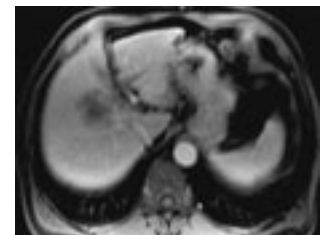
Contrast enhanced MRI at 6 months follow-up after DEB TACE demonstrates significant reduction in tumor size consistent with partial using RECIST
